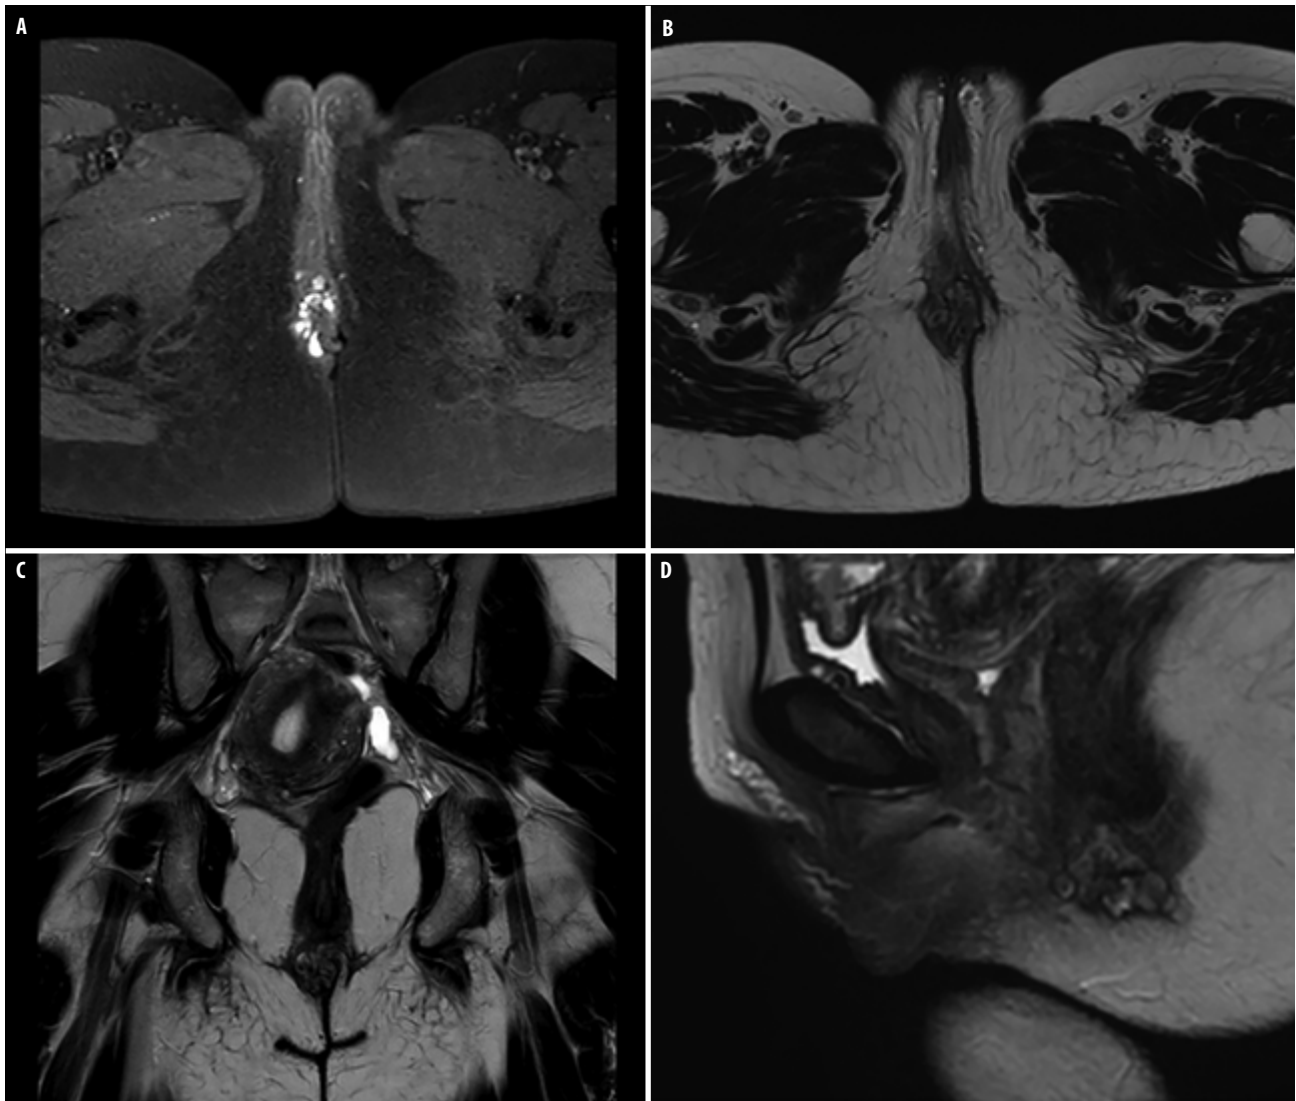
Pelvic MRI shows right perineal lesion. (A) Axial T1-weighted image, (B) axial T2-weighted image, (C) coronal T2-weighted image, (D) sagittal T2-weighted image
